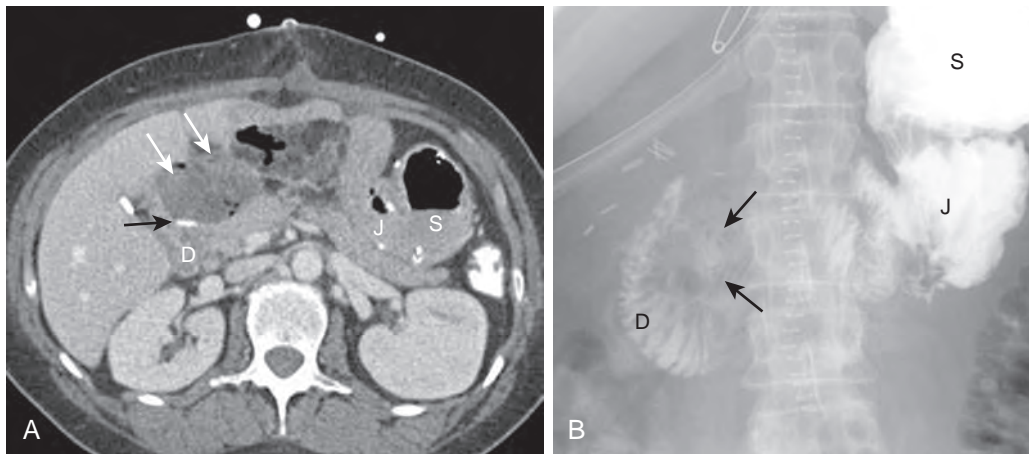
Duodenal stump leak after Billroth II. A. Axial contrast-enhanced CT scan shows the stomach remnant (S) anastomosed to the jejunum (J) with a clip (black arrow) in the vicinity of the oversewn duodenal stump (D). There is a fluid collection containing gas anterior to the duodenal stump (white arrows). Also note foci of adjacent extraluminal gas. B. Supine UGI image shows the Billroth II anatomy with a small amount of reflux in the afferent limb opacifying the duodenal stump (D). There is an amorphous collection (arrows) of contrast, confirming a duodenal stump leak.
